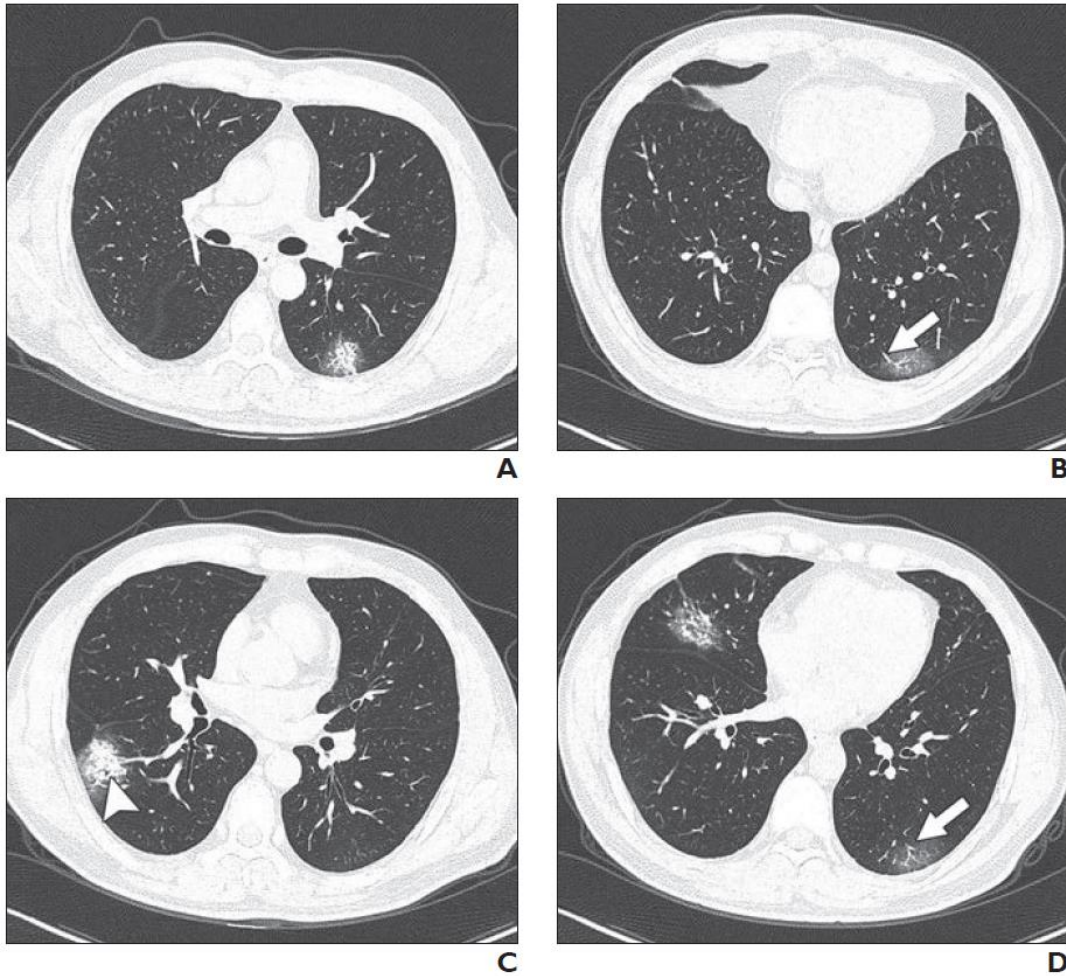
37-year-old man with confirmed coronavirus disease (COVID-19), common type. Patient had short-term exposure history to Wuhan and onset symptoms of fever (38°C) and cough. CT was performed on day of admission.
